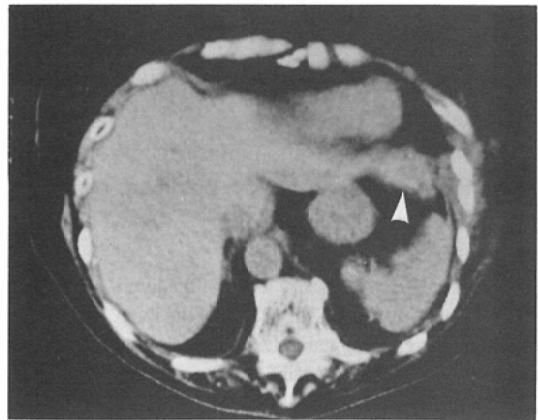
CT. Left anterior oblique scan. The accessory lobe of the liver (arrowhead) extended to the left from the lateral segment of the left lobe of the liver.
